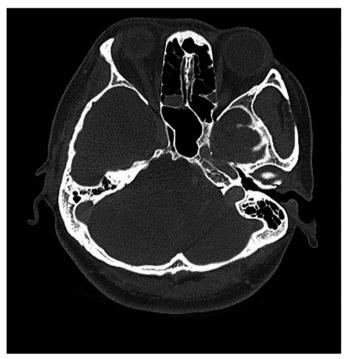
Follow-up cranial computed tomography for the osteosarcoma scan was completely negative.
